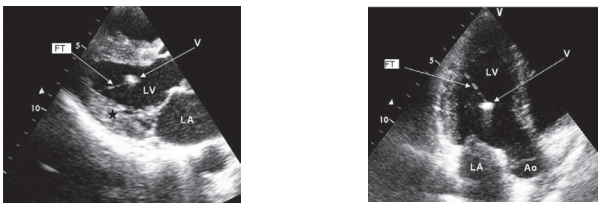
Parasternal long axis view showing vegetation and left-ventricular false tendon originating from below the papillary muscle (FT: left-ventric
